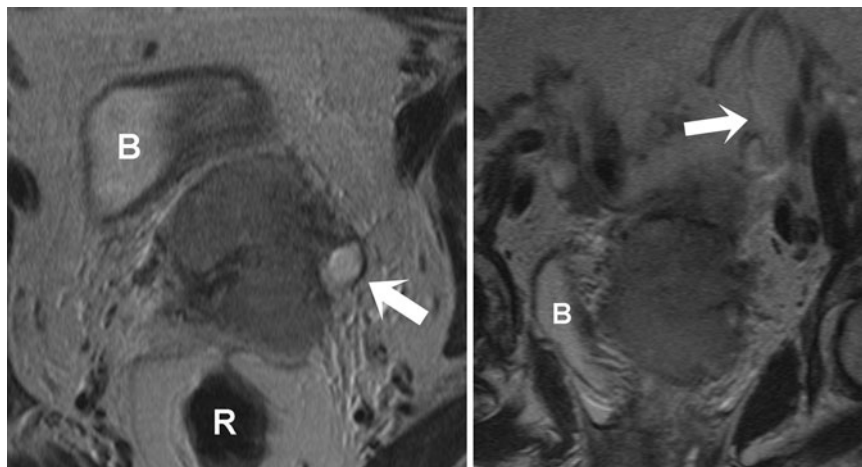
Cervical mass with parametrial infiltration and obstruction of the left ureter (white arrow) in a T2-weighted sequence with high spatial resolution in the transversal and coronal planes. Cervical carcinoma stage T3b. B: bladder, R: rectum.
